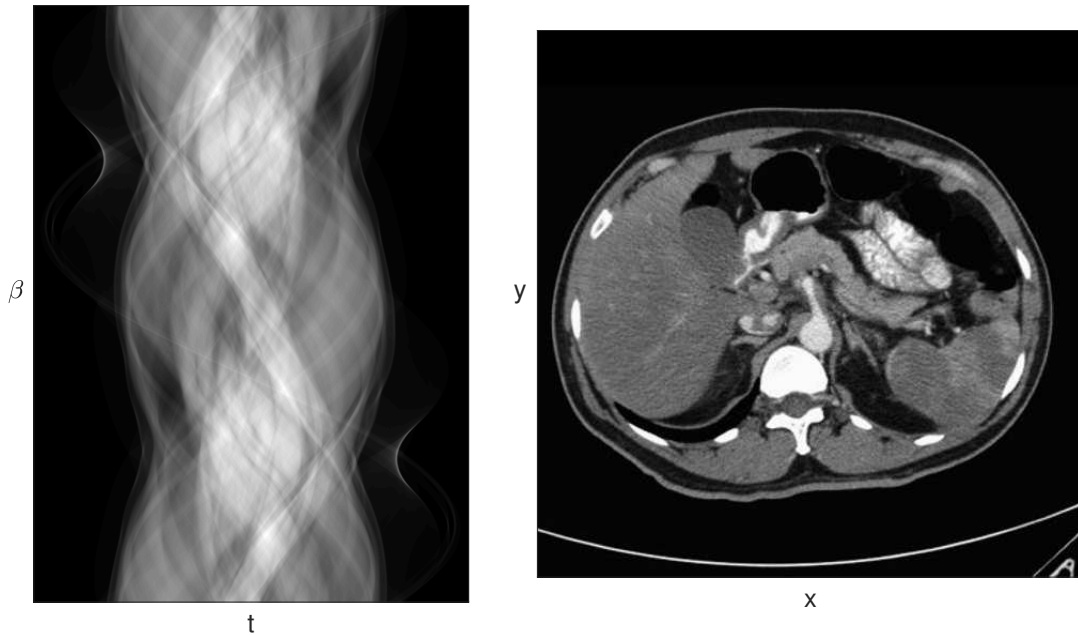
The sinogram-reconstruction pair: left) An CT sinogram is a collection of projections from different view angles from 0 (bottom) to 2π (top); right) a reconstructed CT image from the sinogram on the left panel.
